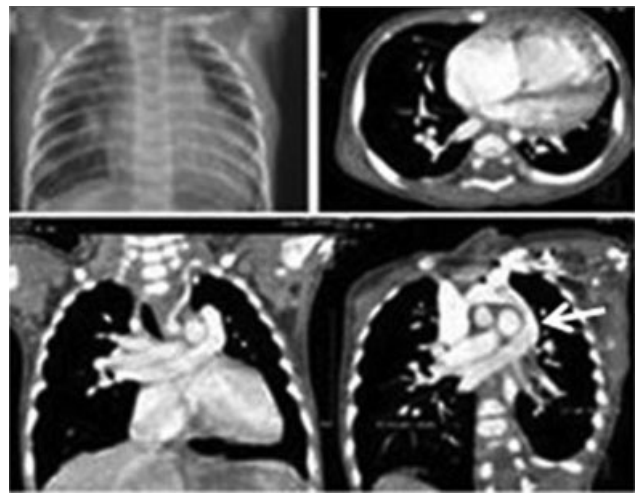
In this child CXR was normal. CT showed supra-cardiac type of TAPVR with all pulmonary veins on right draining into left SVC (vertical vein, marked by a white arrow), then into right brachiocephalic vein and normal SVC. TAPVR, total anomalous pulmonary venous return.
